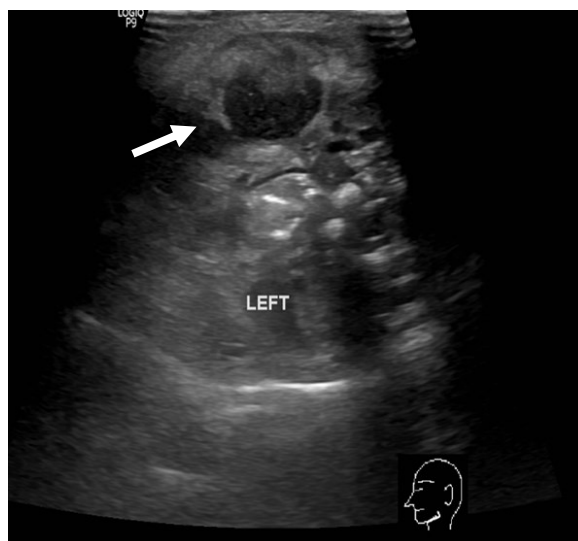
Ultrasound neck showing abscess collection at the left submandibular region measuring 1.6cm x1.8cm x1.6cm, suggestive of an abscess.
